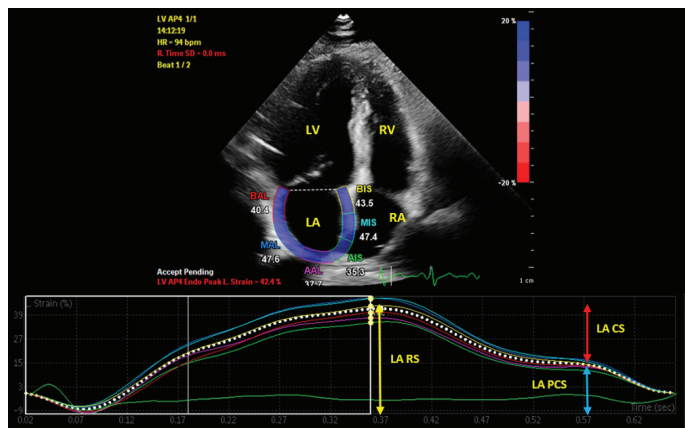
Left atrial strain imaging using 2D speckle-tracking echocardiography from the apical four-chamber view in a study patient. The yellow arrow indicates reservoir strain (RS), the blue arrow indicates peak contraction strain (PCS), and the red arrow indicates conduit strain (CS).
